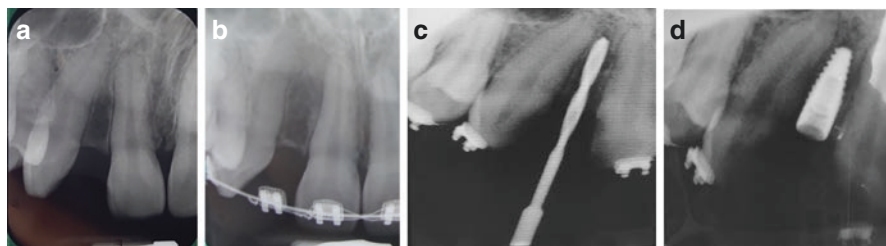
(a) Lack of enough space for implant placement, (b) orthodontic therapy for space creation, (c) navigating the implant position via radiograph, (d) Implant placement
